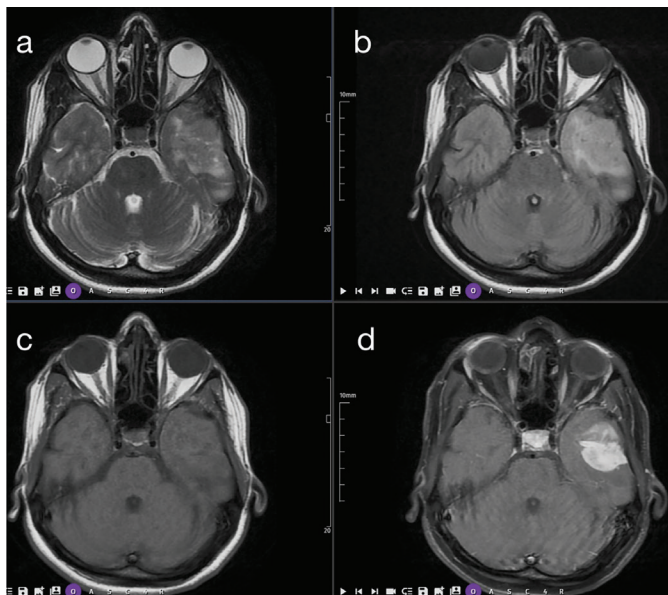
Preoperative magnetic resonance imaging of the left temporal lobe mass. A 32×27 mm space-occupying lesion demonstrates hyperintense signal on T2-weighted (a) and fluid-attenuated inversion recovery (b) sequences, hypointense signal on T1-weighted imaging (c), and homogeneous contrast enhancement on post-contrast fat-suppressed T1-weighted sequences (d) in axial planes. The lesion is located in the left temporal lobe with associated mass effect
